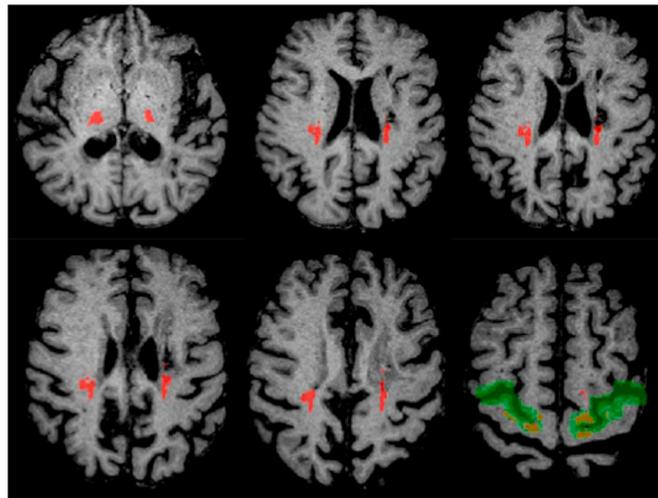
Thalamic projections to premotor cortex are shown in red on a series of T1-weighted axial slices from ventral to dorsal. The premotor cortex target mask is shown in green. The thalamus seed masks are shown in Figure A1.
